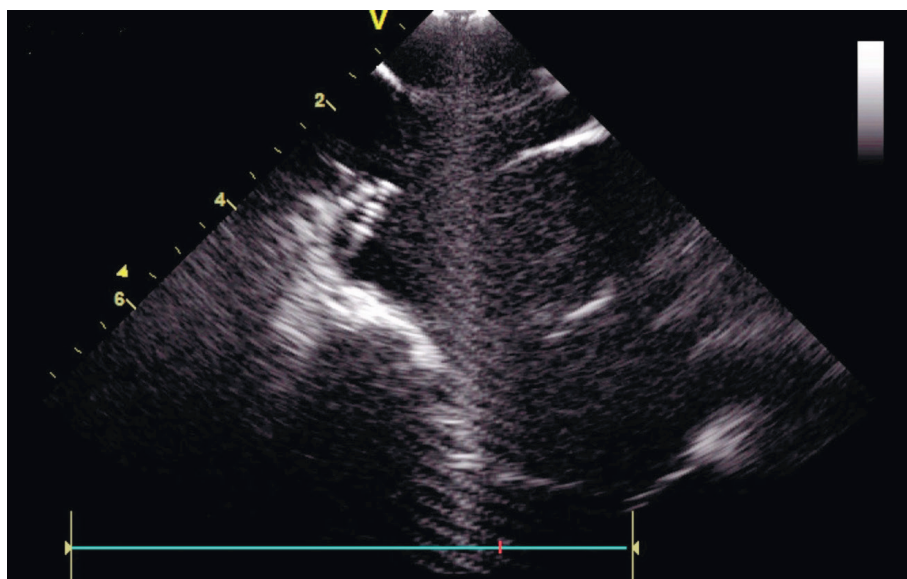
Radiofrequency ablation of cavotricuspidal isthmus under control of intracardiac echocardiography.
